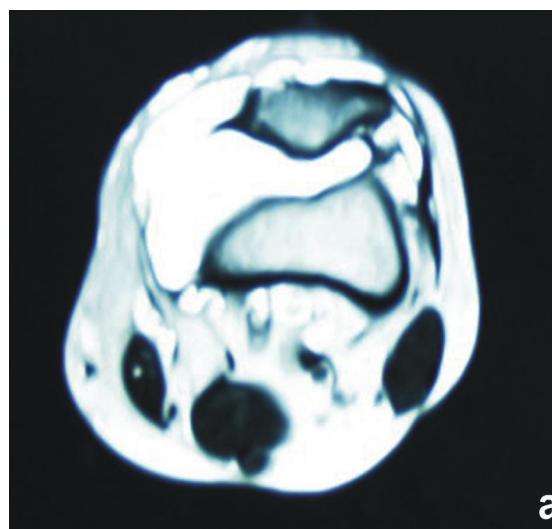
(a) Axial Transverse W MRI showing hypertrophic and villous proliferation arising from synovial lining
